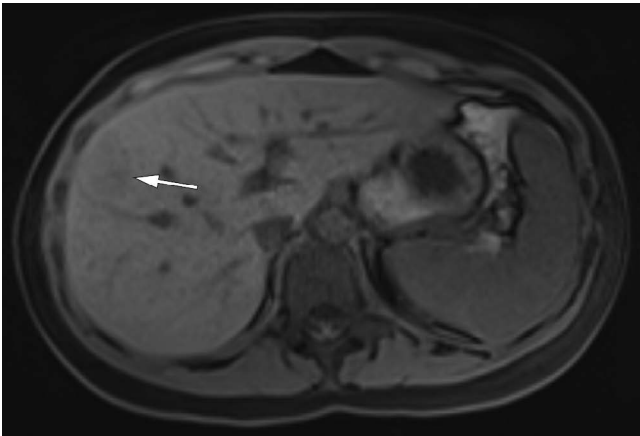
Focal nodular hyperplasia (FNH). Annotated. Liver. MRI. T1 weighted. Fat suppression. Precontrast. Axial plane. An arrow points to a right hepatic lobe mass, which proved to be an FNH.
